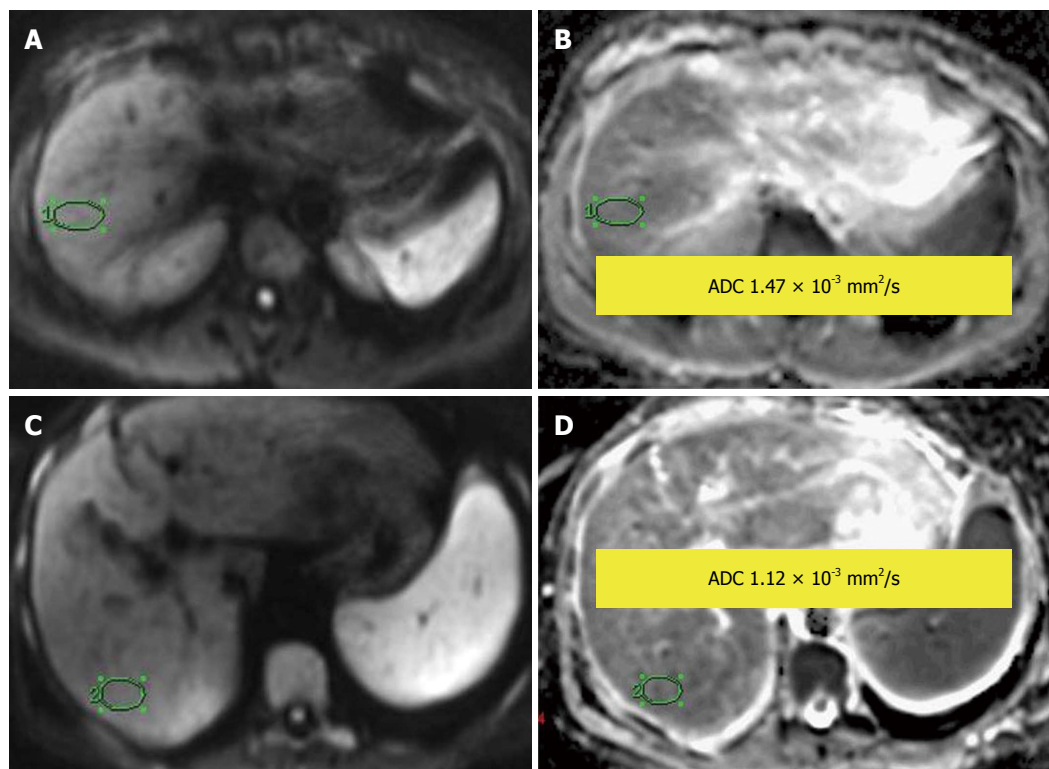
Normal liver parenchyma. A, B: Diffusion-weighted image (DWI) (A) and apparent diffusion coefficient (ADC) map (B), showing ADC = $1.47 \times 10^{-3} \text{ mm}^2/\text{s}$; Liver cirrhosis: (C) DWI and (D) ADC map, showing ADC = $1.12 \times 10^{-3} \text{ mm}^2/\text{s}$.
